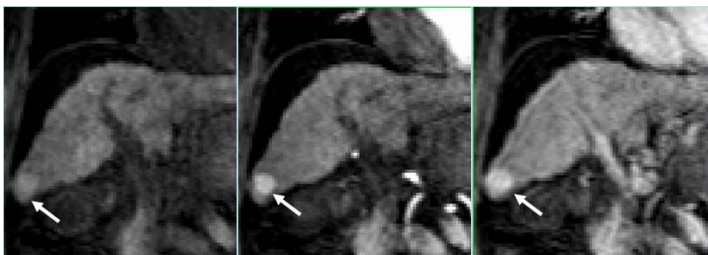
Representative images from liver DCE-MRI acquisition are shown, pre-contrast (left), aorta (center), portal venous phase (right), in a cirrhotic patient with HCC located in segment 6 (arrow).
